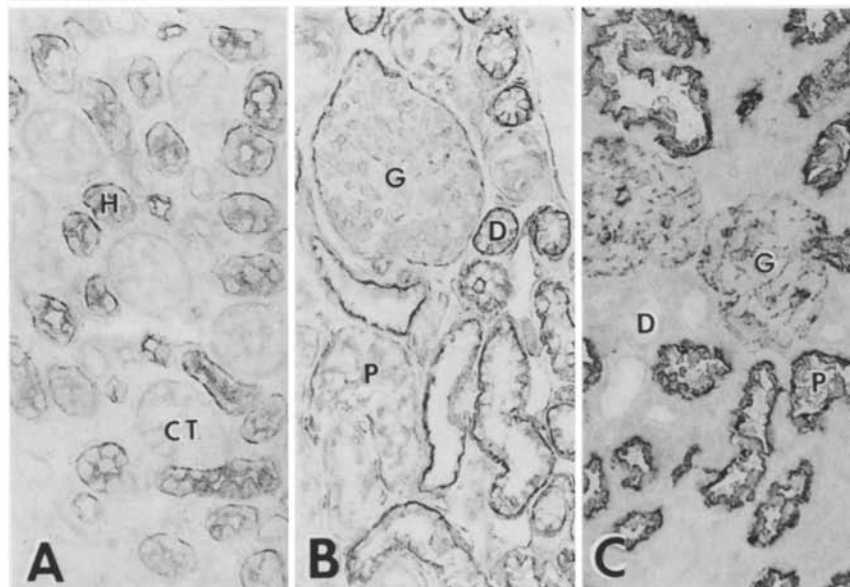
Adult renal tissue. A BA-1 reacted with the Henle's loop (*H*) but not with the collecting tubules (*CT*). $\times 150$. B BA-2 reacted with distal tubules (*D*). $\times 150$. C CALLA was positive on proximal tubules (*P*) and glomerular epithelium (*G*). $\times 160$
